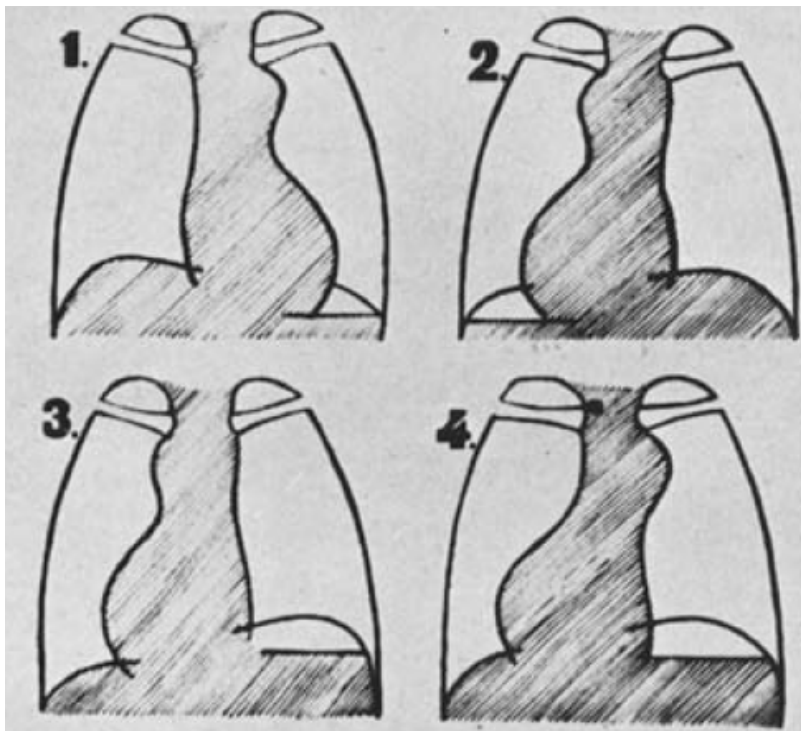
X-ray appearance of the different types of congenital dextrocardia. (1) Normal. (2) Complete inversion of viscera (Type I). Reversed image compared with normal. (3) Congenital isolated dextrocardia with inversion of cavities. Abdominal viscera normally placed (Type II). (4) Isolated dextrocardia, with normal interrelation of cavities and left-sided aortic arch (Type III). Note the position of the diaphragmatic domes. Adapted from Reinberg and Mandelstam, 1928^{1,3}
